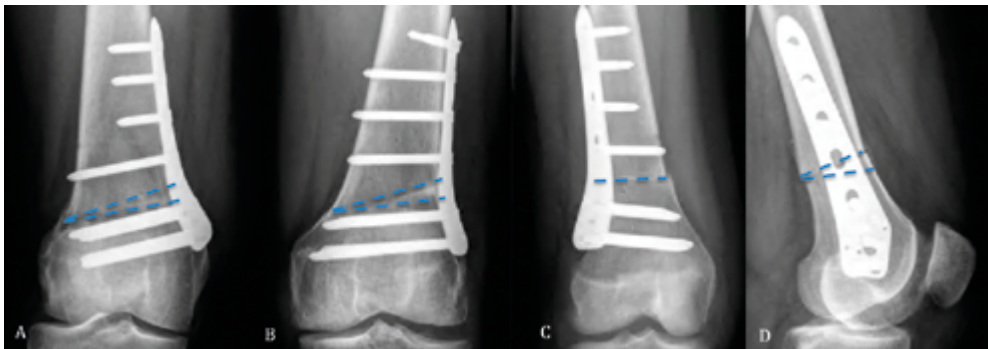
Postoperative anteroposterior/lateral radiographs of distal femoral osteotomies (DFOs) with projected osteotomy cuts (striped lines). A Right knee after medial closing wedge DFO, B Left knee after lateral closing wedge DFO, C Right knee after de-rotation DFO, D Left knee after anterior closing wedge DFO
